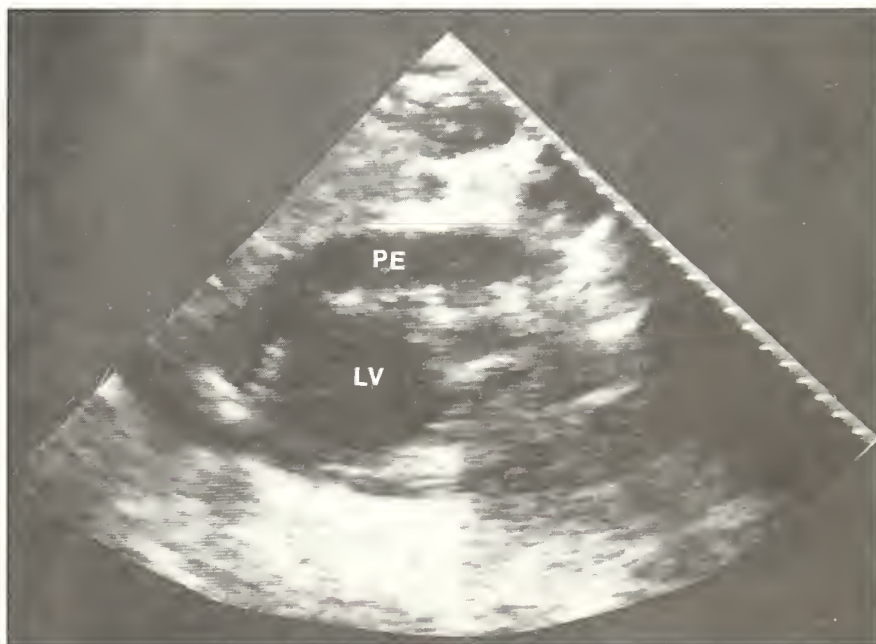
Modified apical two-chamber view showing a moderate pericardial effusion surrounding the left ventricle.
